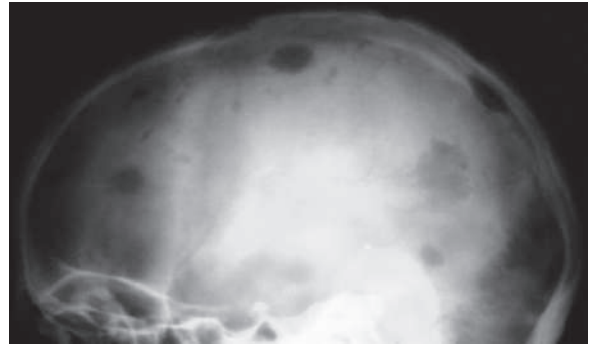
Lateral plain skull radiograph of a patient with multiple myeloma shows multiple, osteolytic, sharply-defined lesions affecting the clavarium
